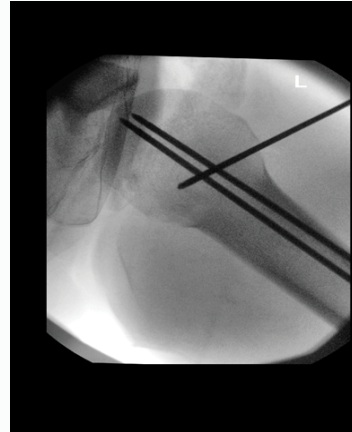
superior- inferior axial x-ray view of left shoulder post k-wiring.
